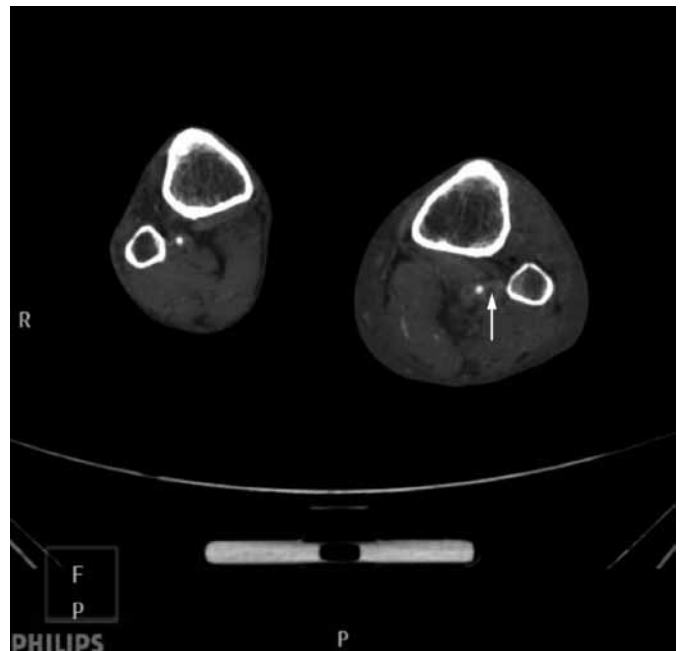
Axial CT of the femur showing total occlusion of left popliteal vein (DVT) due to haematoma above.
